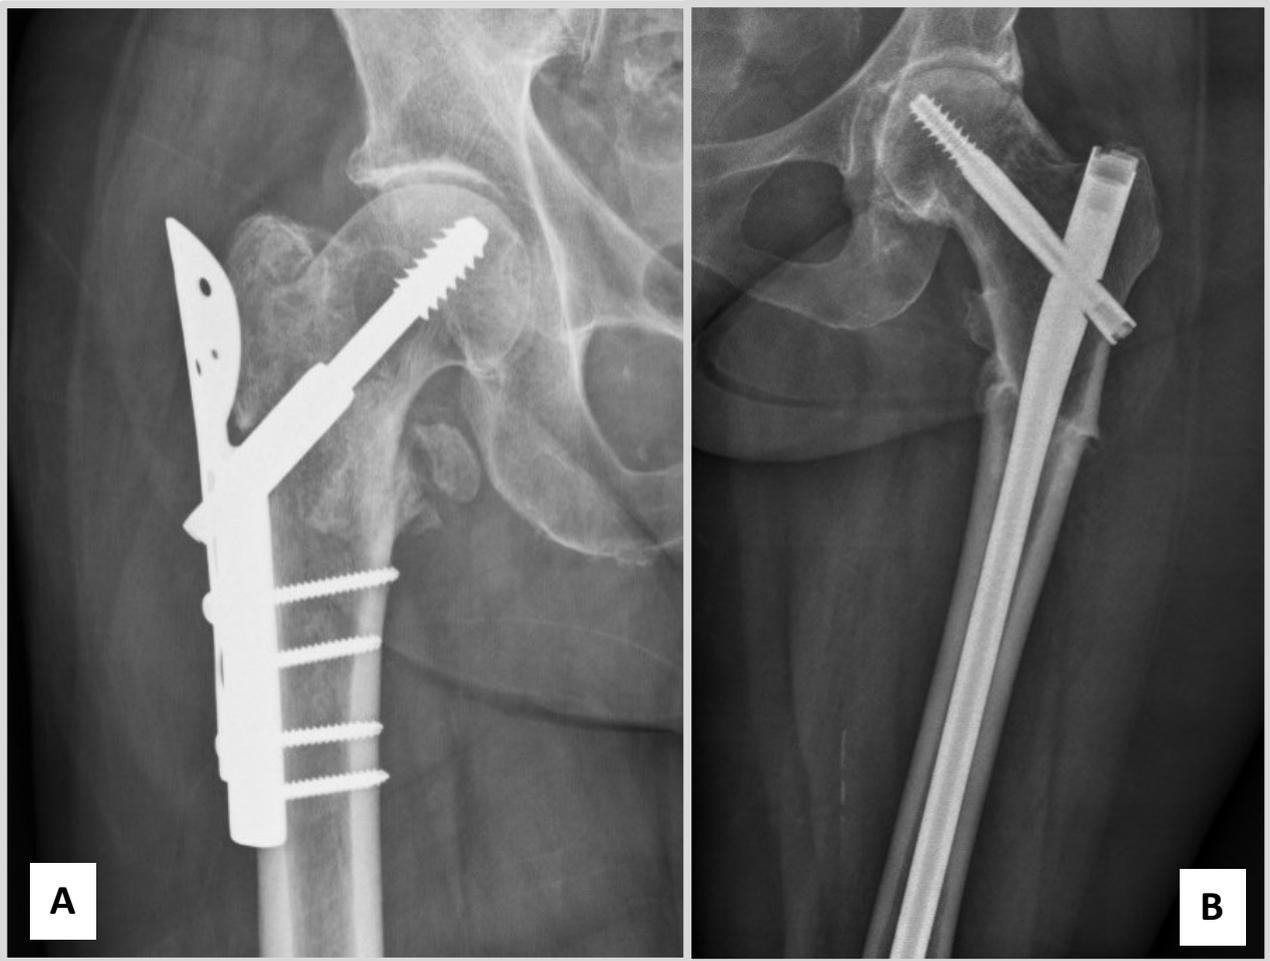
X-ray showing (A) the dynamic hip screw with trochanteric stabilizing plate and (B) the intramedullary nail without cerclage.
